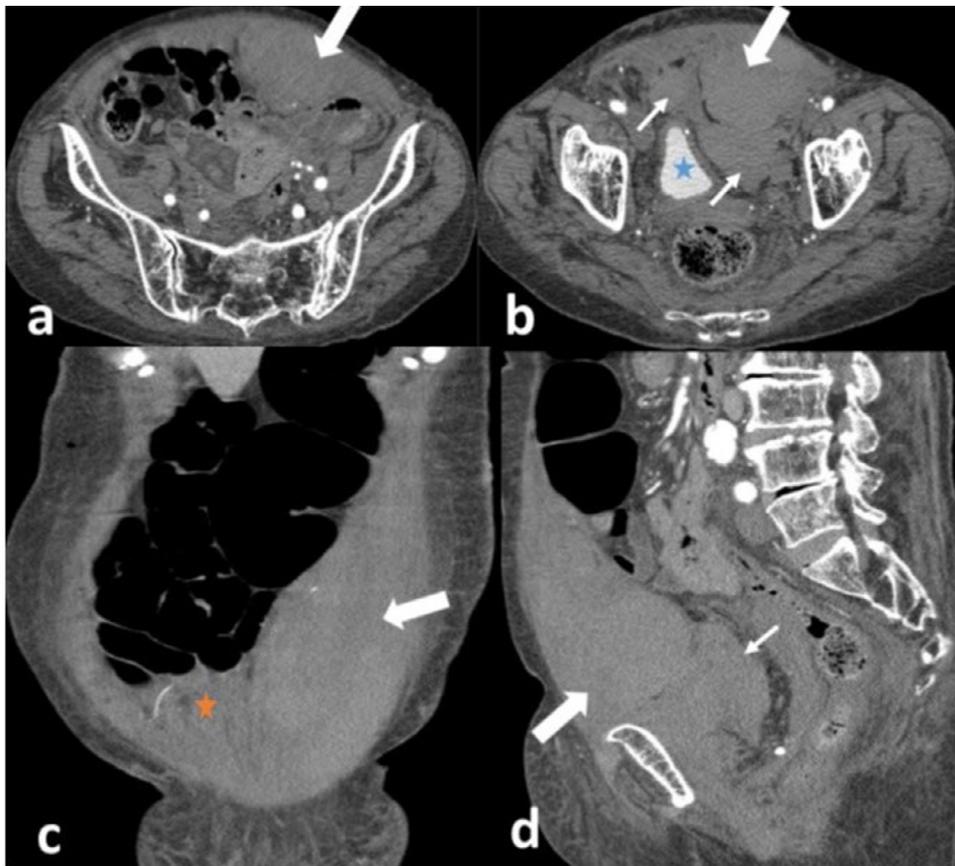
Type III rectus sheath hematoma[?]. Axial (a,b), coronal (c) and sagittal (d) contrast-enhanced abdominopelvic computed tomography shows left rectus sheath hematoma (thick arrows). The hematoma extends below the arcuate line, into the pelvic cavity and the pre-perivesical space (thin arrows).
